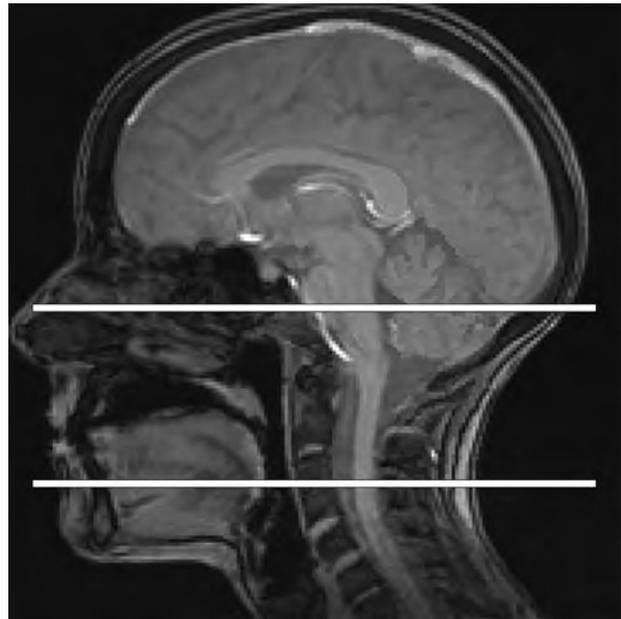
Sagittal midline localizer MR image. Horizontal white lines through the basiphoid and cranial aspect of the extrinsic tongue muscles serve as an accurate approximation for the CISS craniocaudal slab selection when imaging the facial nerve.
